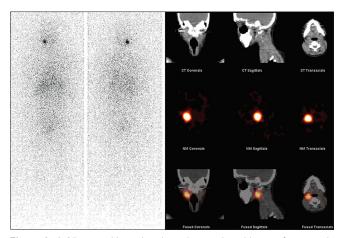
A 25 year with neck pain and a previous history of metastatic involvement of cervical lymph nodes by neuro-endocrine tumor was referred for lodine-131 metaiodobenzyl guanidine (MIBG) study. The scan showed a focus of MIBG uptake in the right side of the neck. Single photon emission computed tomography/computerized tomography localized the uptake to the region of carotid artery bifurcation indicating carotid body tumor
